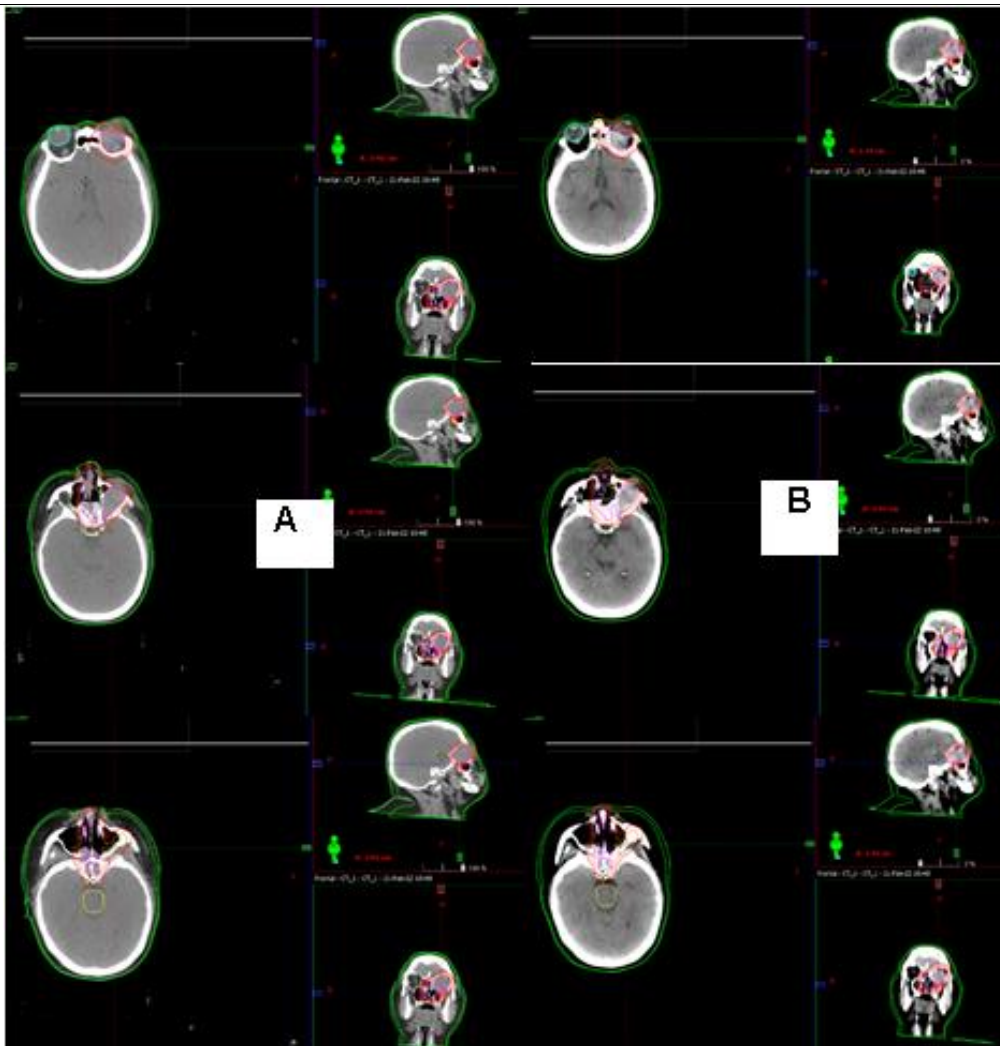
Comparison of the tumor volume through the planning CT A/ of 2022 before RT with the one of 2025/ February 3 years after the radical RT - visible reduction in the nasal part of the tumor volume with residual sphenoid and left -sided retrobulbar tumor.
